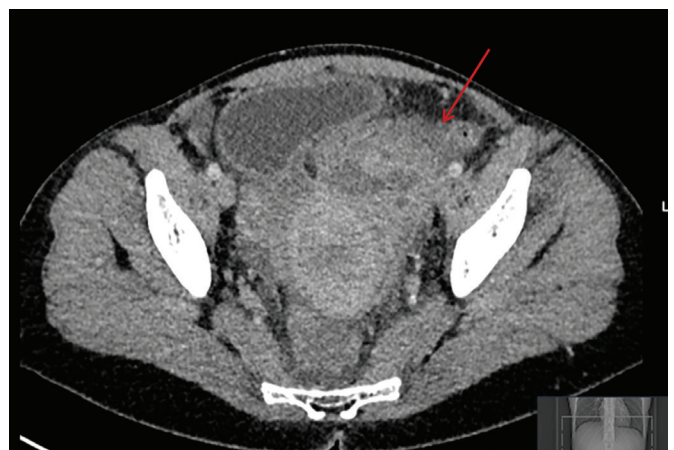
Axial computed tomography of the abdomen and pelvis demonstrating a complex collection within the left pelvis, located between the uterus and the left ovary posteriorly.
